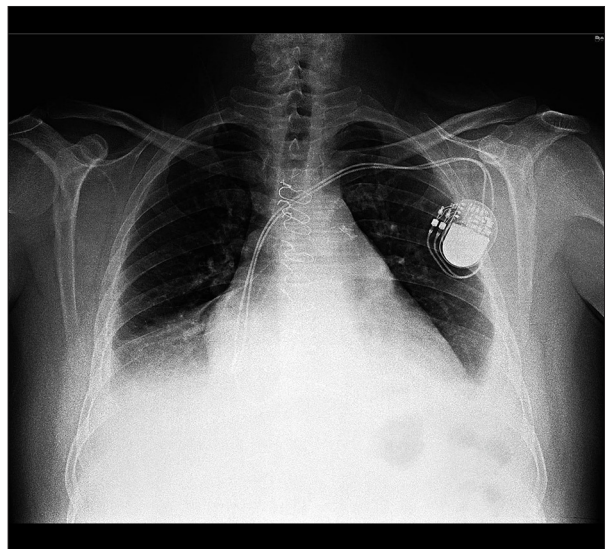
Chest X-ray after dual-chamber pacemaker implantation.
